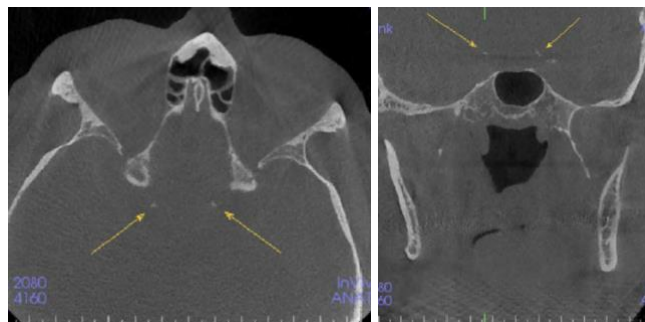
Axial (left) and coronal (right) CBCT cross-sections showing circumferential calcifications within the cavernous segments of the internal carotid artery
